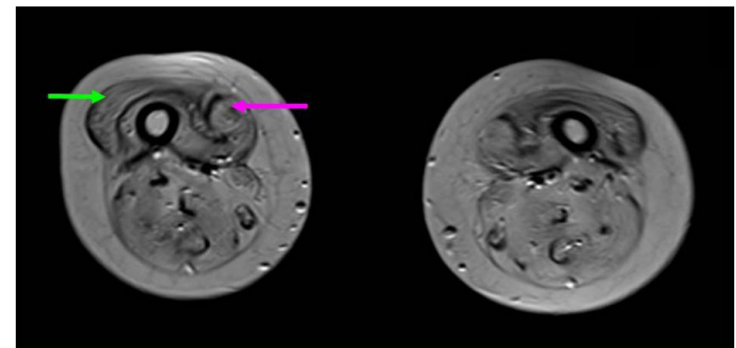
Improvements on the MRI-MSK after autologous BMMNCs transplantation.
